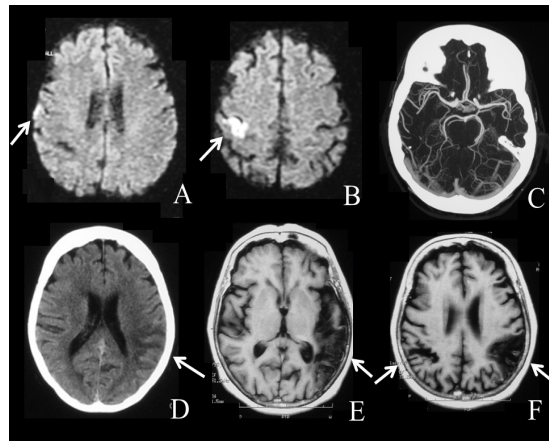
A and B. Cranial MRI, diffusion sequences showed two right cortical ischemic lesions (white arrows). C. Intracranial CT angiography showed normal vessels. D. Cranial CT on second admission showed a left ischemic stroke (white arrow). E and F. Cranial MRI, T1 sequences showed a chronic bilateral ischemic stroke (White arrows)
